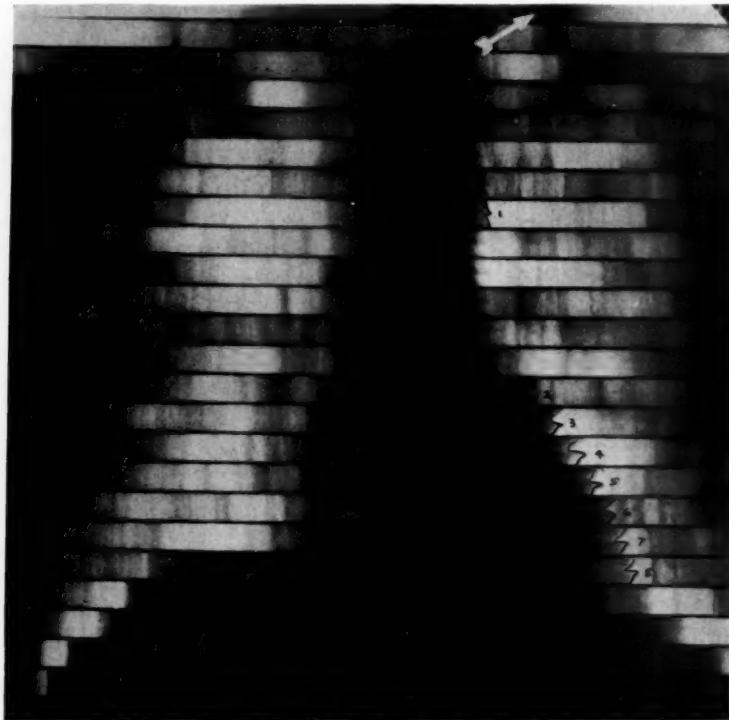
Normal roentgenkymogram, from a normal man, 50 years old.
